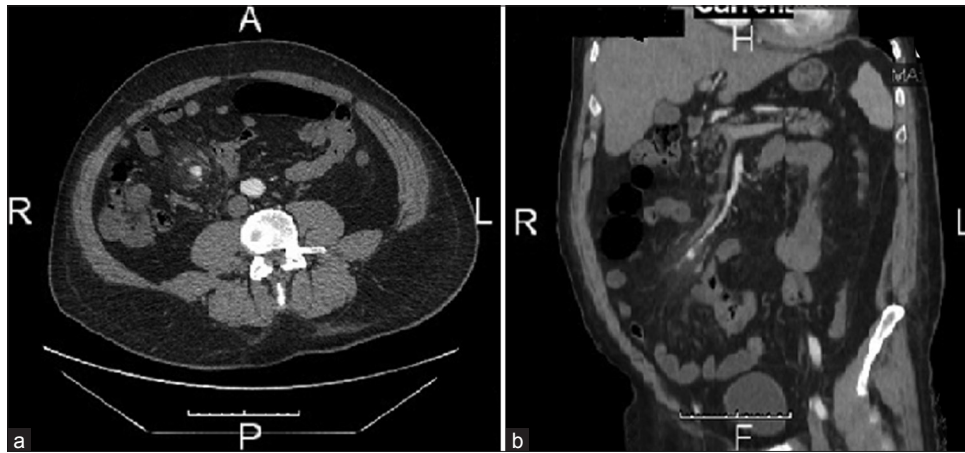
CT Scan abdomen and pelvis showing aneurysm in ileocolic artery of superior mesenteric artery (a) transverse (b) coronal
